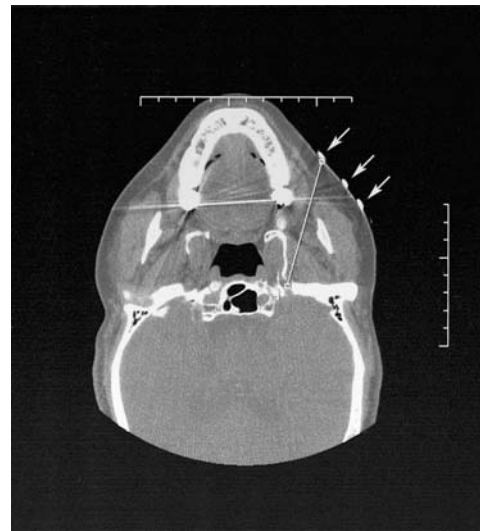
The safe and shortest route to the foramen was designed on the CT image (Case 1). The *arrows* show the marking devices
